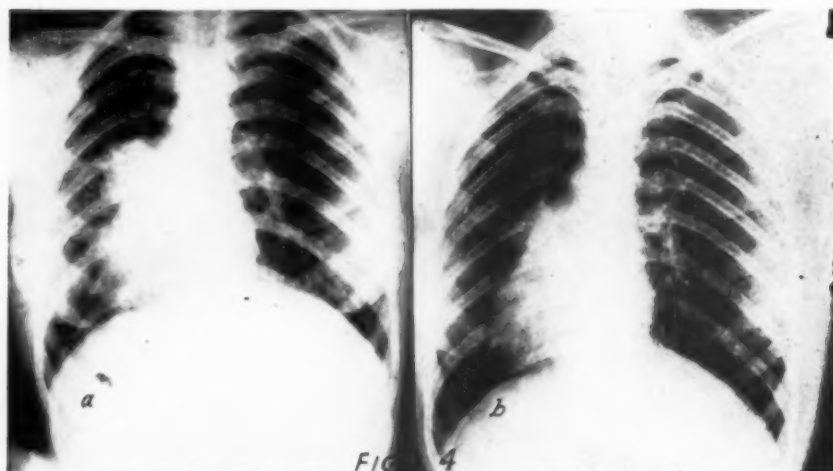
(a)—Acute inflammatory type of hilus pneumonia in an adult. Radiograph, made within a few hours after the initial chill, shows that the maximum extent of the consolidation is attained within a short time. (b) —Complete resolution within two weeks.
